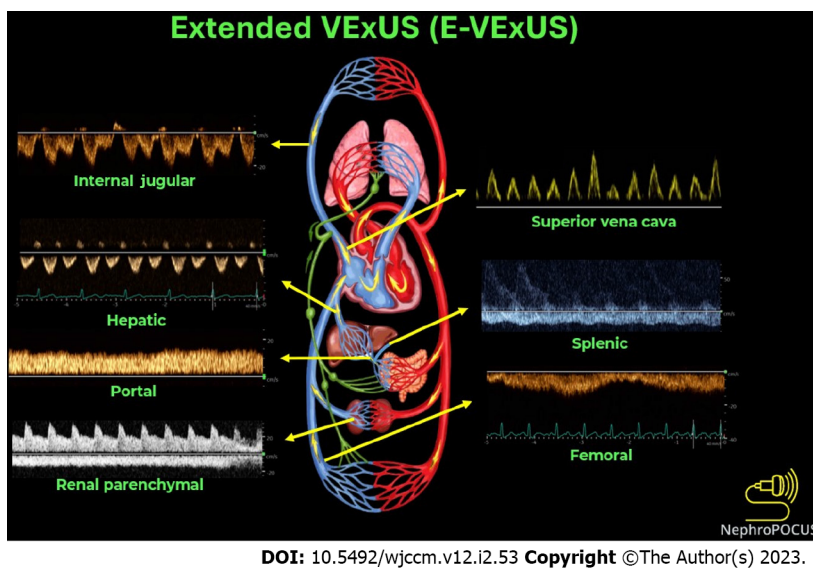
Doppler components of extended venous excess ultrasound score examination. Figure adapted from NephroPOCUS.com with permission.
